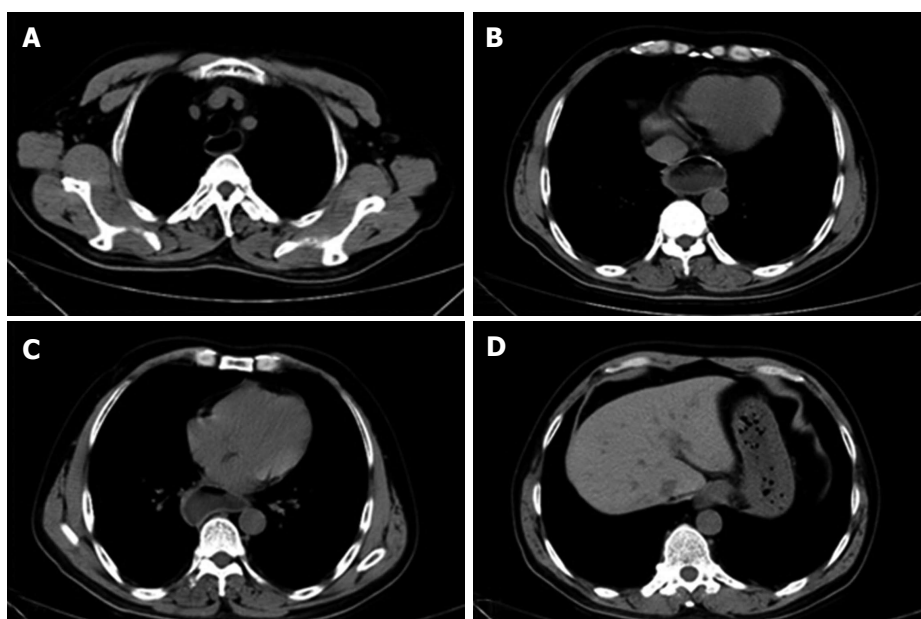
Chest computed tomography examination showed that the esophageal cavity was obviously expanded (A-C); large amount of fluid retention was seen in the lumen (D). The cardiac muscle layer was significantly thickened.
